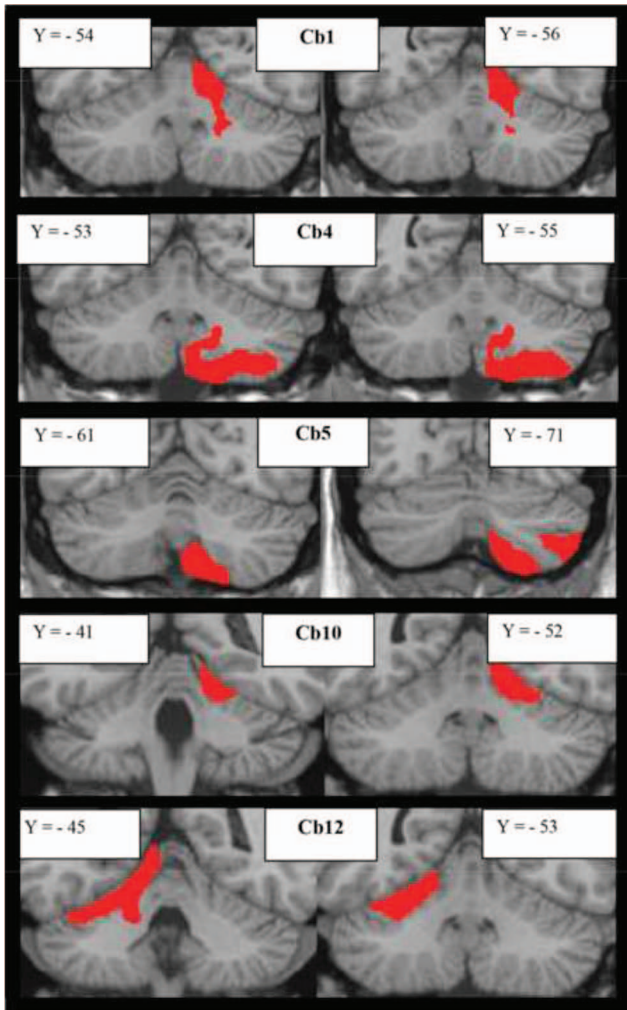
Participants with focal cerebellar lesions. Lesion extensions were assessed on the 3D-T1-MPRAGEs after spatial normalization and overlaid onto the coronal T1-weighted template from the MRI Atlas of the human cerebellum (Schmahmann, Dojon, Toga, Petrides, & Evans, 2000). For each participant, the lesion is presented in two representative coronal sections. See the online article for the color version of this figure.
